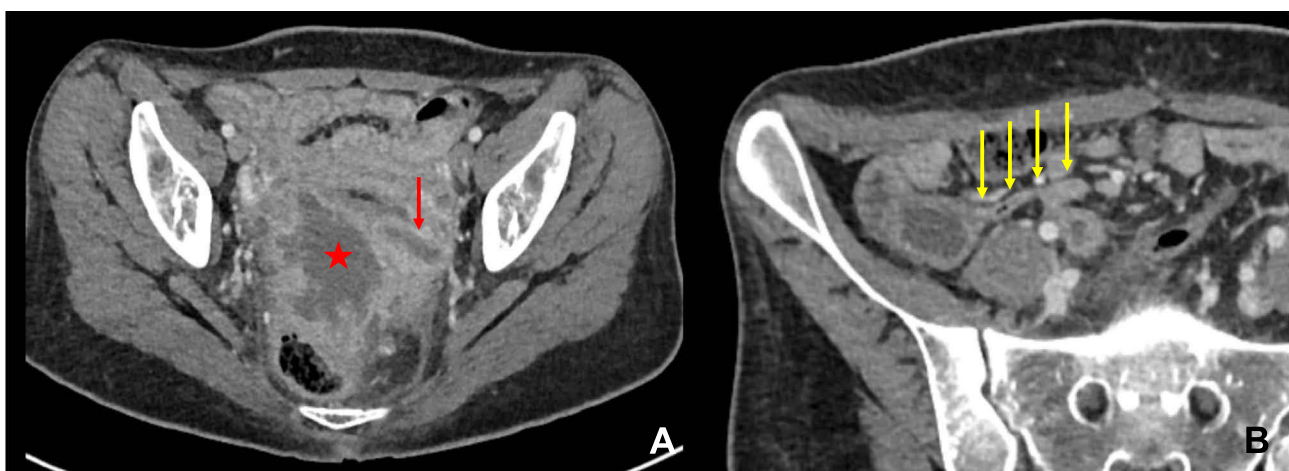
Computed tomography (CT) images. (A) Cystic mass (red star) in the lesser pelvis with peripheral enhancement, suspicious of an abscess. Additionally, left salpingitis with pyosalpinx (red arrow) is also visible in this image. (B) The appendix is slim and shows no signs of inflammation (yellow arrows).
